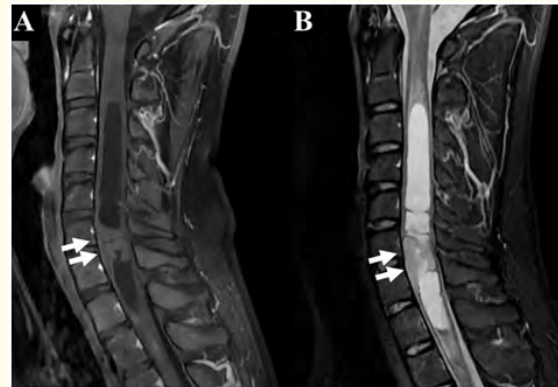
Initial MRI findings at first presentation.
